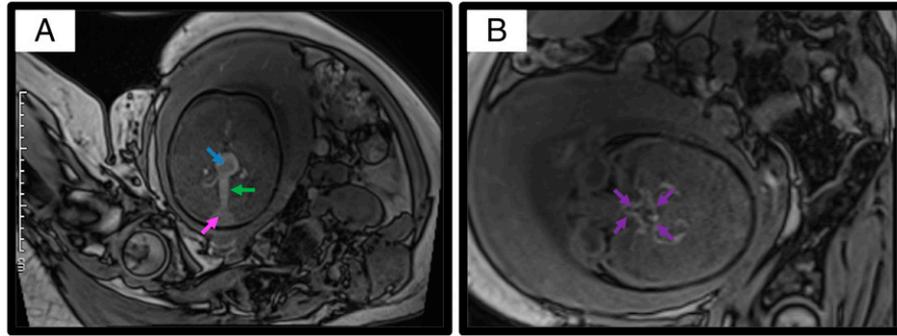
Axial T1 magnetic resonance imaging at 37 weeks' gestation showing the fetal brain. A. Choroidal type vein of Galen malformation (VOGM) demonstrating dilation of the persistent embryonic median prosencephalic vein (blue arrow), as well as dilation of the straight sinus (green arrow) and transverse/sagittal sinus confluence (pink arrow). B. Enlarged arteries in the circle of Willis (purple arrows) suggesting a high shunt flow.
